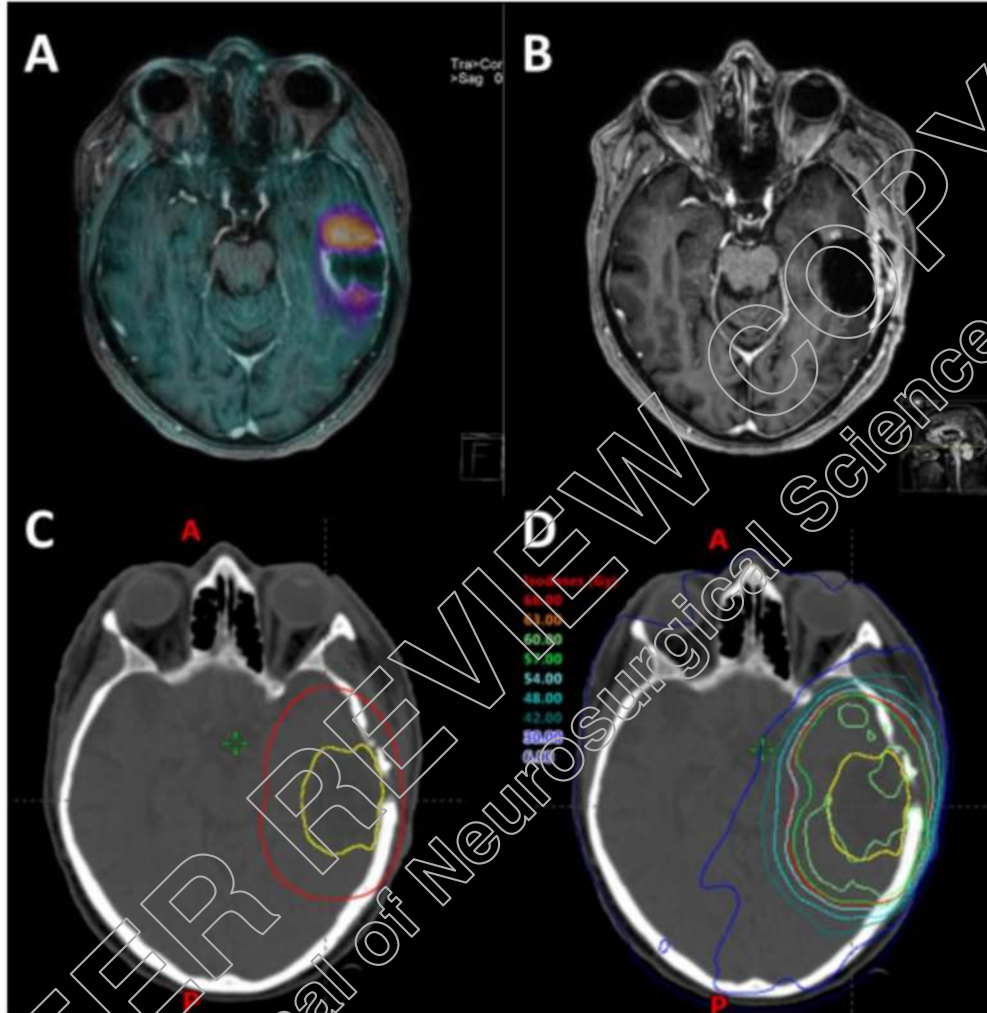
A case of a GBM patient treated in our hospital. A) contrast enhanced T1 sequence with overlying FET-PET image before resection. B) contrast enhanced T1 sequence after resection. There is a small remnant at the rostral edge of the resection cavity. C) Planning CT, PTV (red) resection cavity (yellow). D) Dose distribution of the RT-plan.
